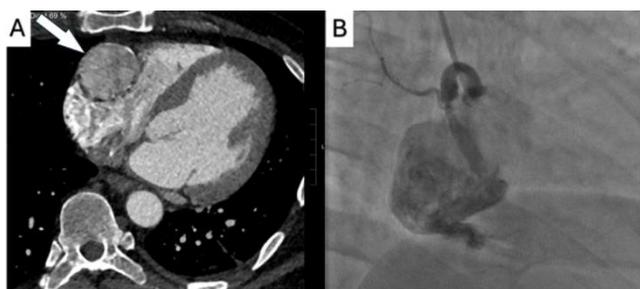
Pre-Operative Imaging of a Giant Right Coronary Artery Aneurysm. A) 4.5 cm right coronary artery aneurysm (white arrow) seen on chest computed tomography. B) Giant right coronary artery aneurysm noted on cardiac catheterization.
